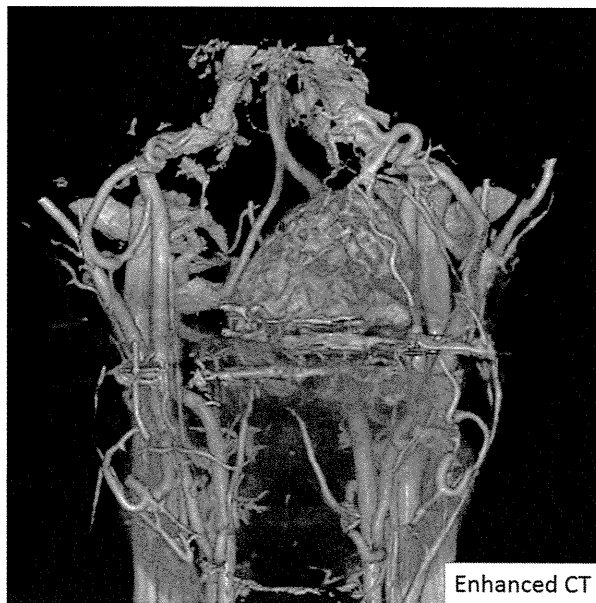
Multidetector CT demonstrated a vascular-rich lesion extending from the upper to middle mucous membranes of the larynx.
